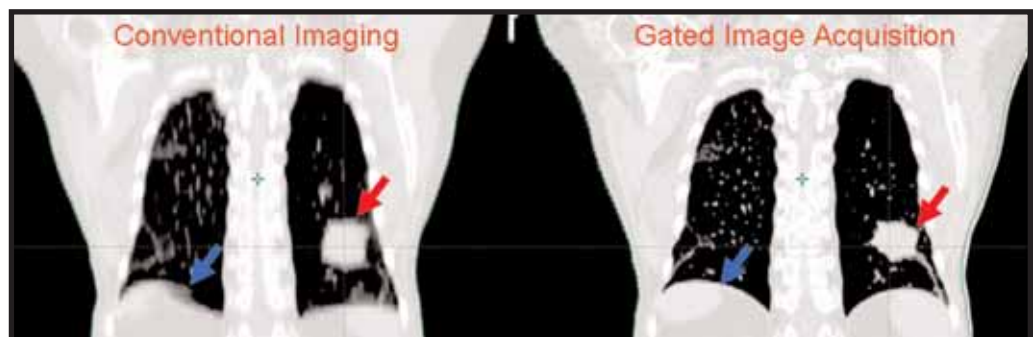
Distortion images seen in nongated (left) and gated 4D CT acquisition (right). Note the larger volume and blurred border (red arrows) and scalloped (“mushroom”) dome of the right hemidiaphragm (blue arrows) compared to gated image acquisition.
